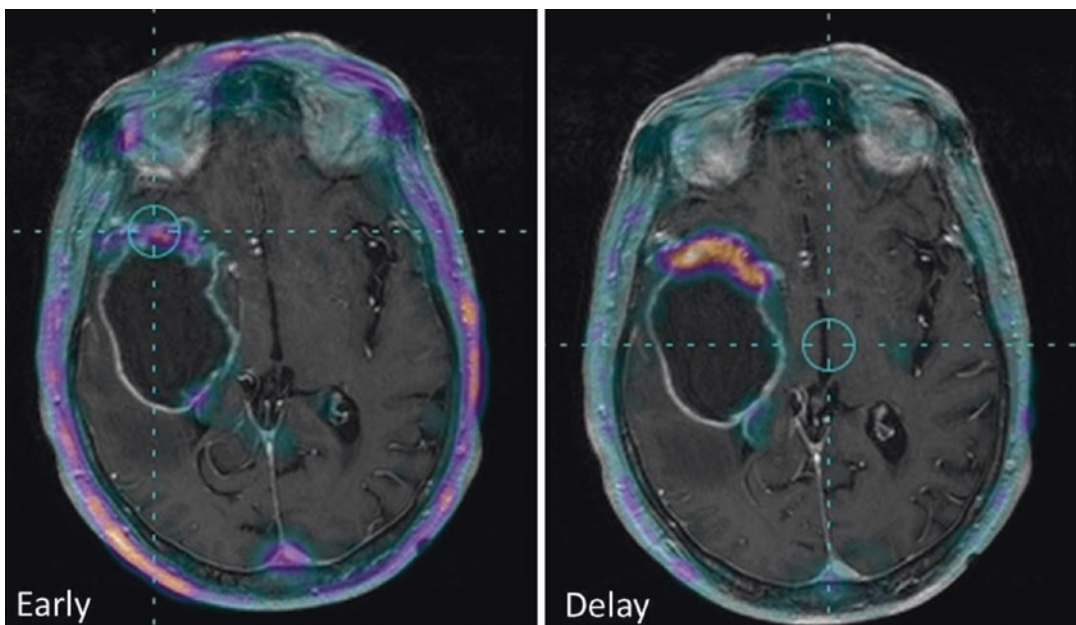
Early (1 h following administration) and delay (24 h following administration) axial ^{64}Cu -ATSM PET/MRI views of the brain, diagnosing tumor relapse in right
